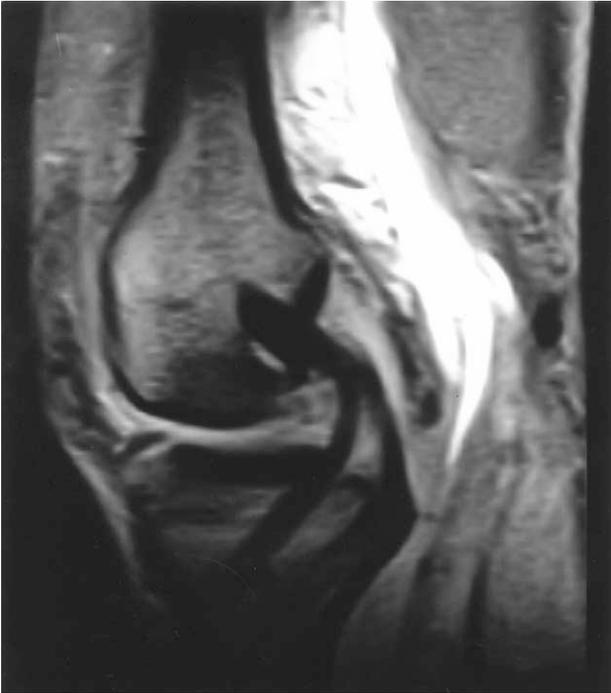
Sagittal magnetic resonance image 1 year after the double-bundle reconstruction of the PCL using double-double tunnel that shows graft continuity.
